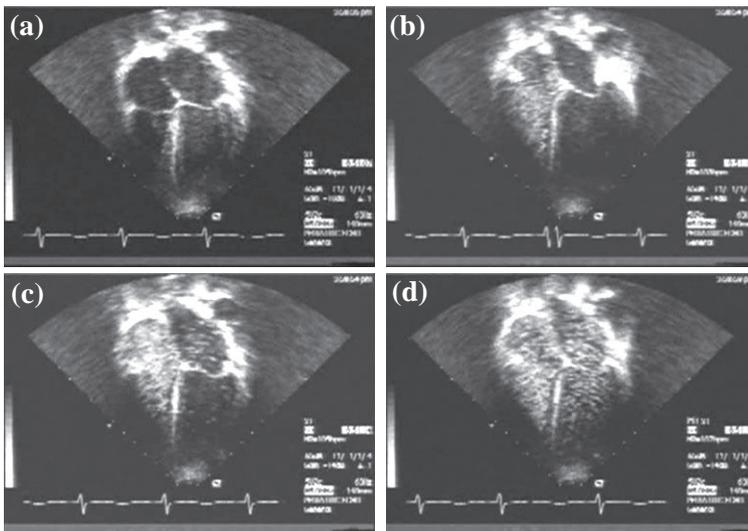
Contrast echocardiography of LKwY. (a) normal four chamber view, (b) immediate after injection, with dense contrast signals in right atrium and right ventricle, (c) four cycles later, bubbles entering the left atrium, (d) contrast signals in both left atrium and left ventricle while still seen in right chambers.
